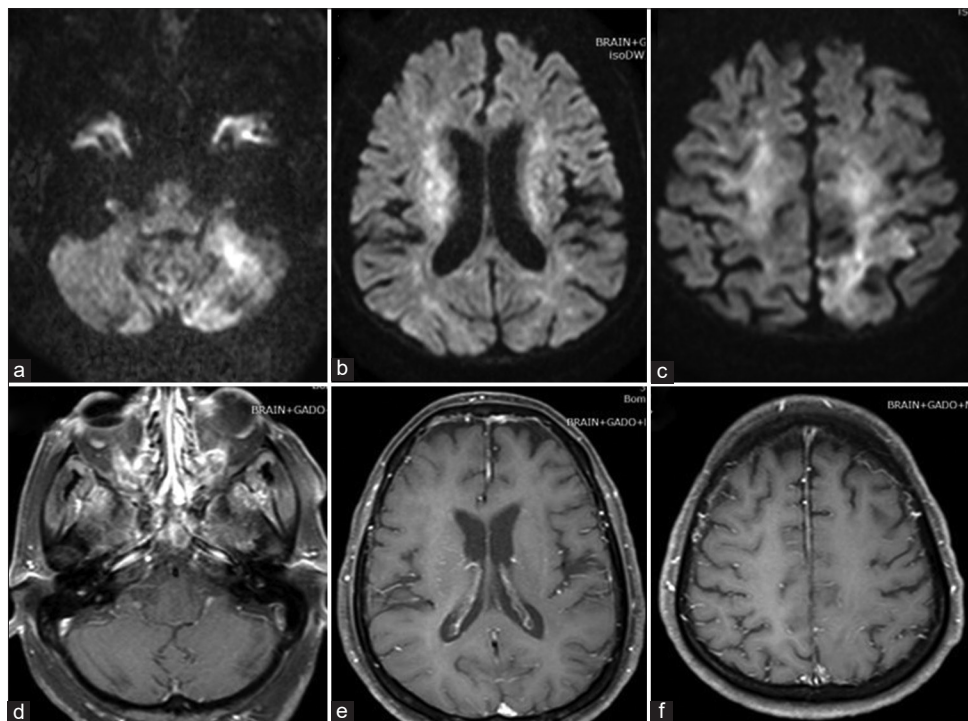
MRI brain of a 53-year-old gentleman with diffusion-weighted images showing restricted diffusion (bright signal) in the cerebellum (a) and cerebral white matter (b and c) with no appreciable post-contrast enhancement (d-f). The FLAIR axial images of the same patient showed ill-defined hyperintense areas. This picture though atypical for lymphoma was highly suspicious from past experience to be consistent with “lymphomatosis cerebri”
